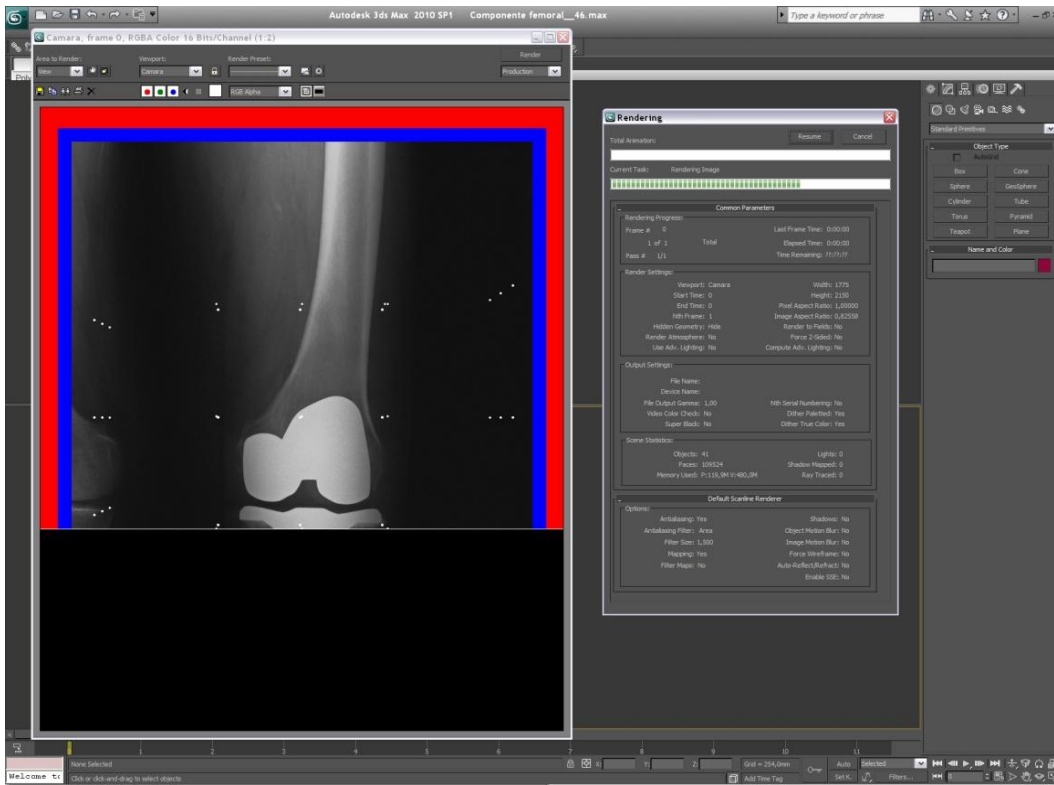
Virtual radiograph
